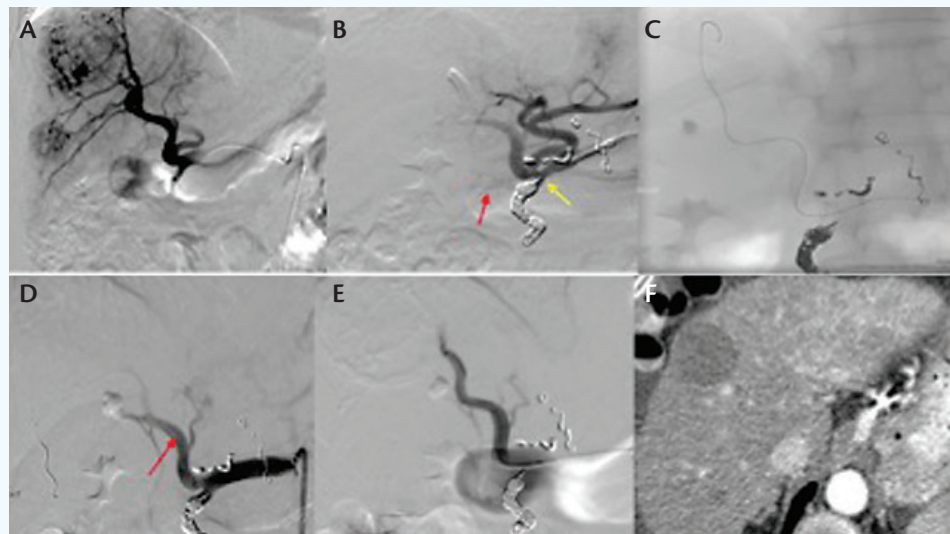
A 58-year-old man with bilateral hepatocellular carcinoma undergoing a mapping procedure for resin radioembolization. The initial digital subtraction angiogram showed large hyper-vascular hepatomas and hepatic arterial anatomy, with close proximity of the gastroduodenal artery (GDA) to right and left hepatic artery origins. Embolization of the GDA was warranted during mapping for resin-coated yttrium-90 spheres due to the higher risk of reflux (A). Embolization of the hepatic falciform artery and right gastric artery was also planned. Postembolization angiogram showed that despite < 1-cm segment of GDA left with flow after coiling (yellow arrow), small duodenal branches were noted coming off the GDA (red arrow) (B). A "final" detachable coil was advanced to GDA; however, it would not fit into the residual proximal GDA segment. The coil was pulled back, and a repeat angiogram showed that the coil detached within the microcatheter, and with contrast injection, the coil migrated to the right hepatic artery (C). After coil retrieval, dissection flap (red arrow) was noted in the proper hepatic artery, which did not resolve after balloon dilation (D). Poststenting digital subtraction angiogram showed restored laminar flow. However, not to lose the chance to treat the patient, bland microspheres were used to treat the right lobe lesions (E). Follow-up CT scan showed complete response of the treated lesions (F).
